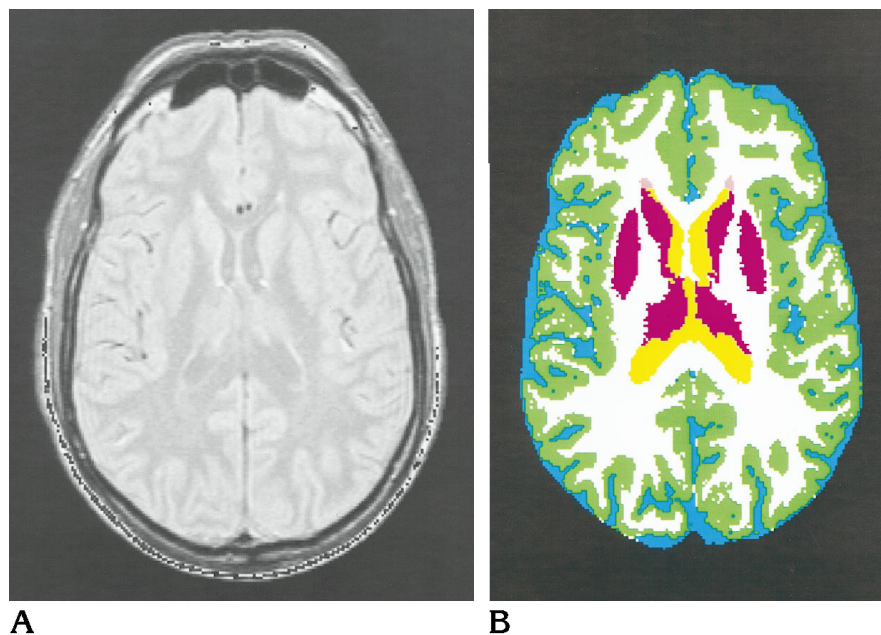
Proton density-weighted (A) and corresponding segmented (B) MR images. Green indicates cortical gray matter; white, white matter; yellow, ventricular CSF; blue, sulcal CSF; purple, subcortical gray matter; and pink, periventricular white matter signal hyperintensity.
